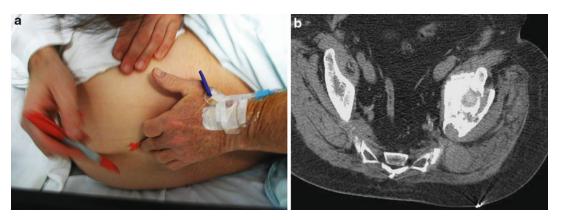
(a) Patients are physically examined prior to the thermal ablation procedure for careful identification of the area of focal pain. The area is marked on the skin. (b) Following application of a metallic marker, CT imaging is used to correlate imaging findings and patient's identified site of pain. The metallic marker correlates
